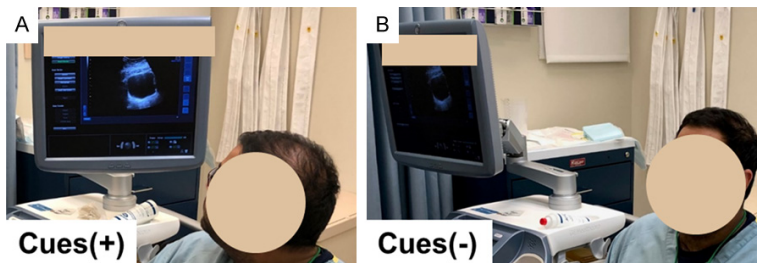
Photos of the experimental setup. Participants were divided into groups with and without auditory/visual (A/V) cues about their bladder volume. A Cues(+) group was allowed to see the bladder ultrasound (US) images and hear communication of their US bladder volumes at 5 min intervals throughout filling (A), and a Cues(-) group was not allowed to see the US bladder images or hear communication of their US bladder volumes (B).
